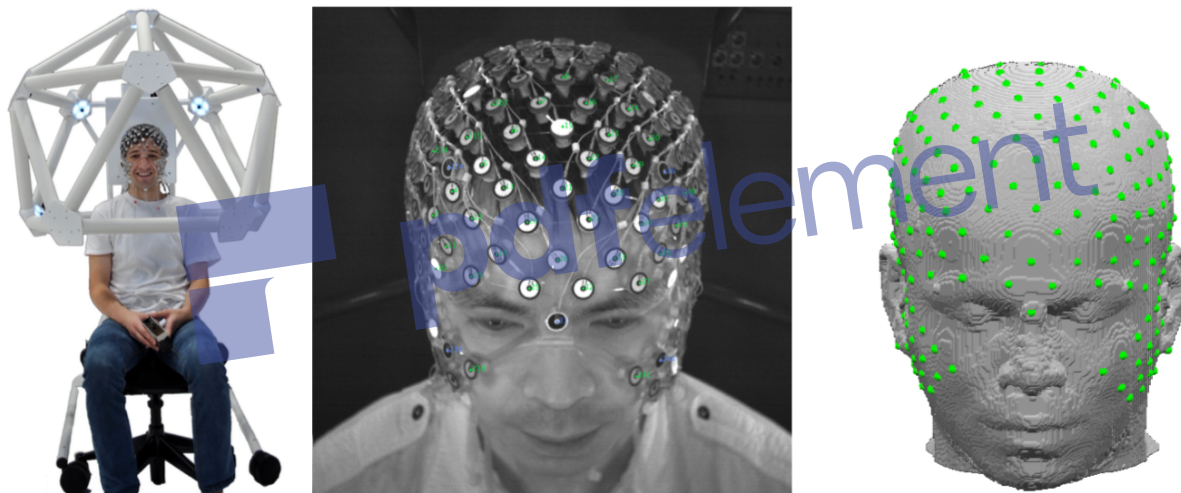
Left: With 11 video cameras, the exact 3D sensor positions are captured with EGI's Geodesic Photogrammetry System (GPS). Middle: the infrared images allow computer vision detection of all sensors in the Geodesic Sensor Net. Right: The 3D sensor coordinates are then registered with the individual's MRI or an atlas to allow precise planning of current delivery in relation to the person's head tissues.
